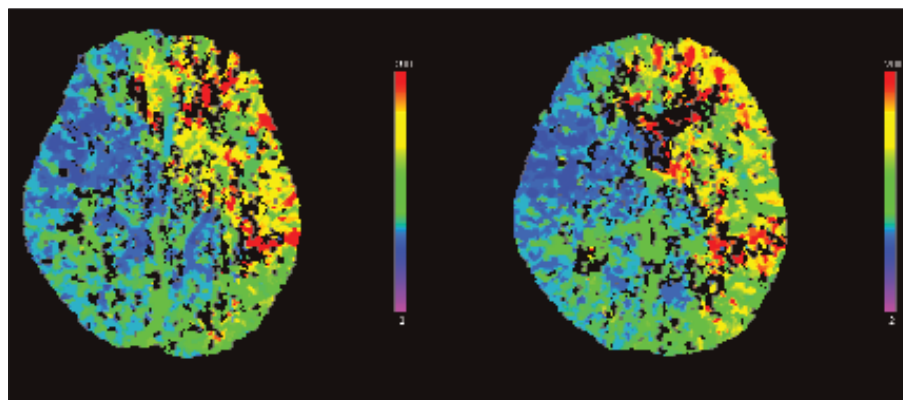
CTP image slice at the level of the frontal horn of the lateral ventricle and the third ventricle. Ischemic penumbra can be seen in the distribution of the left middle cerebral artery. The color map depicts red as poor flow and blue-green as normal flow. These images display ischemic penumbra without ischemic core (Somatom Sensation 64-slice CT scanner, Siemens Healthcare, Malvern, PA).
